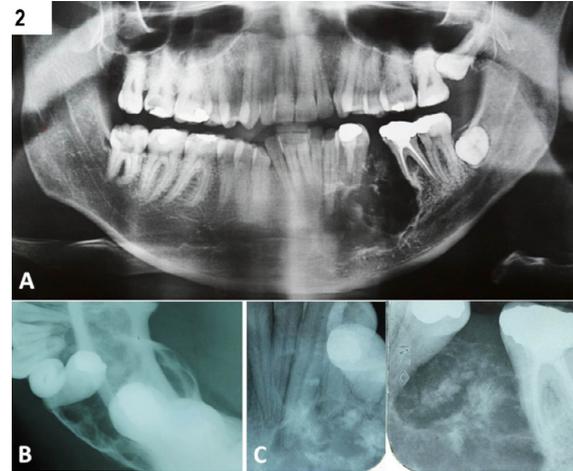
Radiographic aspects of the case. (A) Panoramic radiography shows a well-defined radiolucent lesion with corticated borders in the left mandibular body. (B) Occlusal radiography showing multilocular bicortical expansion without apparent cortical perforation. (C, D) Periapical radiographs showing the lesion with well-circumscribed borders and radiopaque content.
